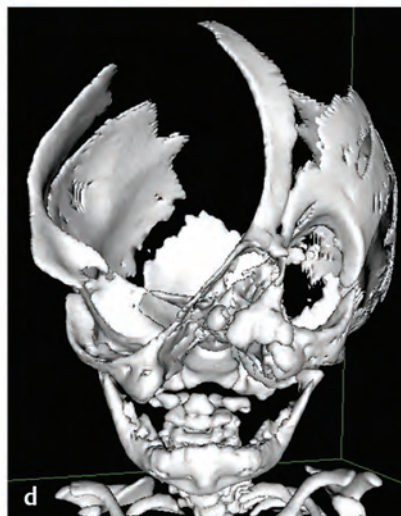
(a) Isolated Tessier number 10 cleft with associated encephalocele. The upper eyelid and brow are distorted, and the hypertelorbitism is characterized by lateral and inferior displacement of the orbit. (b) By comparison, this number 10 cleft has an associated incomplete form of a number 4 cleft, with a previously repaired cleft lip, mild perinasal deformity, shortened naso-ocular distance, and inferiorly displaced medial canthus. (c) The number 10 cleft can be associated with massive encephaloceles, as in this case with a complex pattern of multiple severe coincident bilateral clefts. (d) CT scan shows the large fronto-orbital defect.
